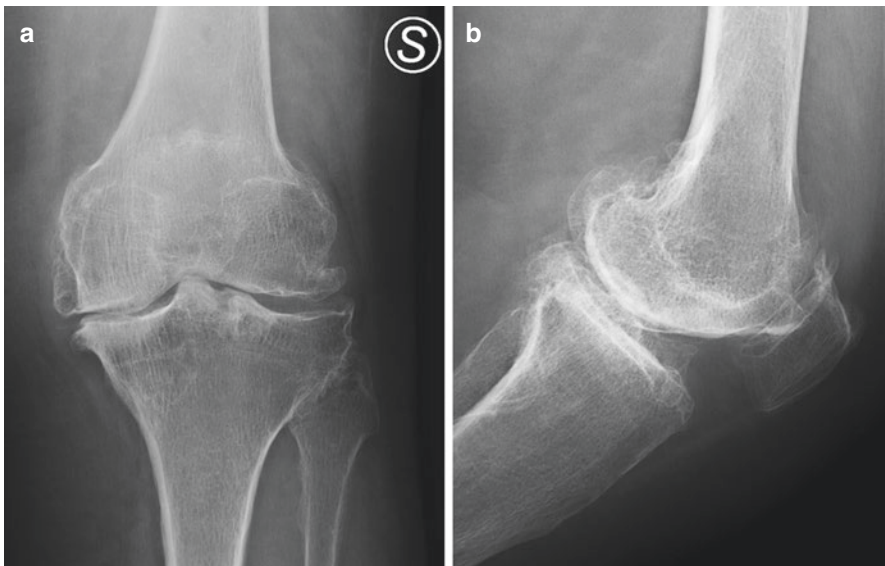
Frontal (a) and lateral (b) plain film view in a patient with knee osteoarthritis showing marked medial joint space narrowing, subchondral bone sclerosis, and osteophytes
